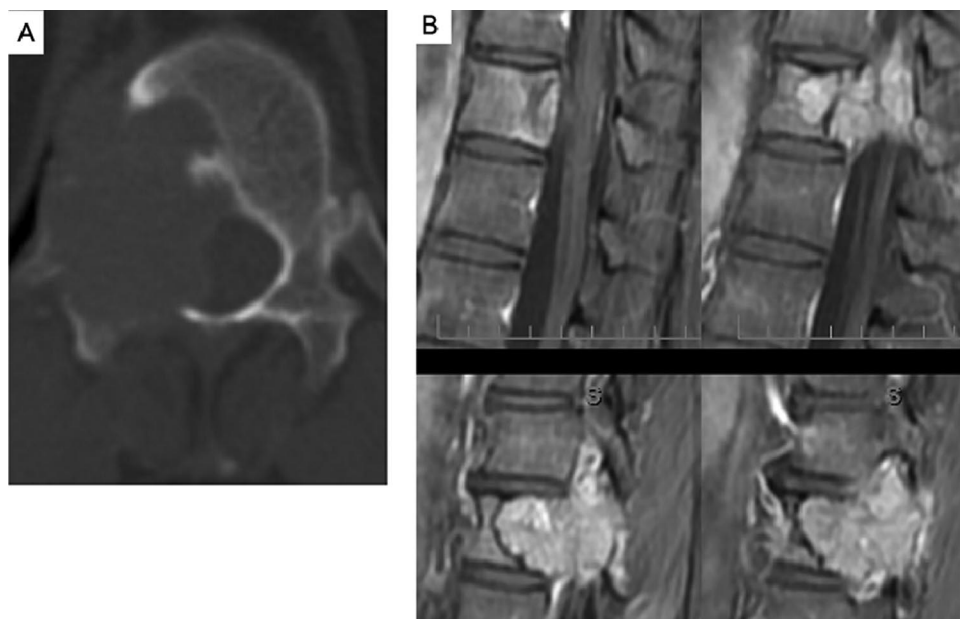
A, Axial CT scan demonstrating lytic lesion of T10 involving severe destruction of the right pedicle. B, Multiple sequential sagittal magnetic resonance images of the metastatic renal cell lesion in T10.
